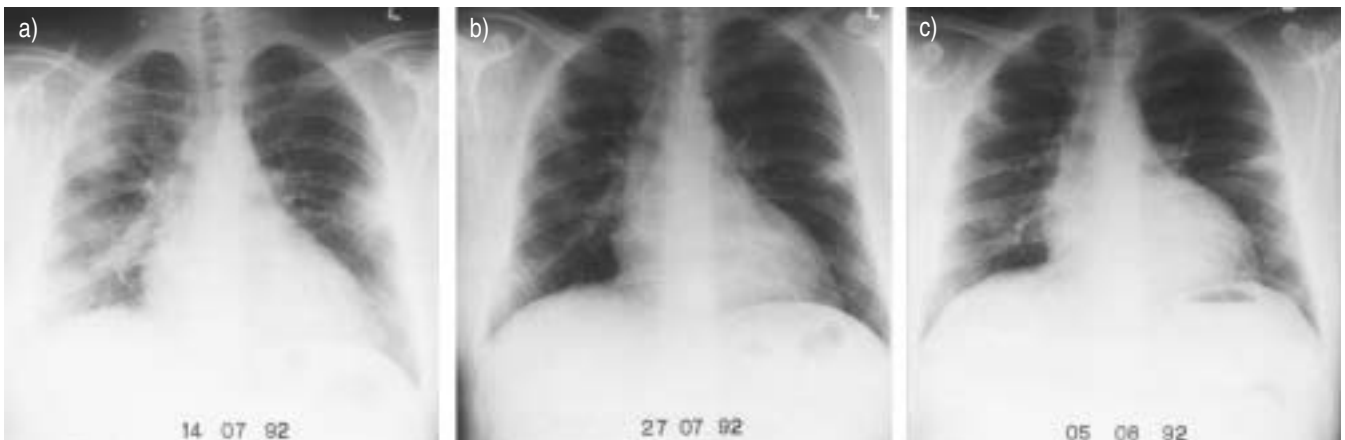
a–c) Serial chest radiographs of a patient with Q fever pneumonia. Note the multiple round opacities. c) Considerable resolution has occurred 3 weeks after the first radiograph.
